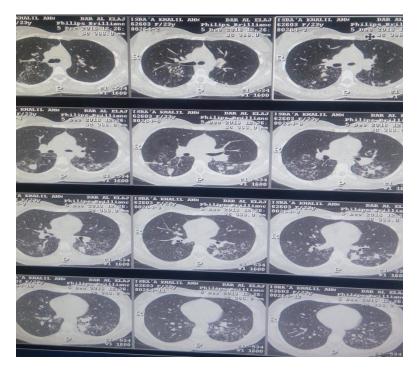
HRCT axial chest for female 23 years old show bronchiectatic change.
